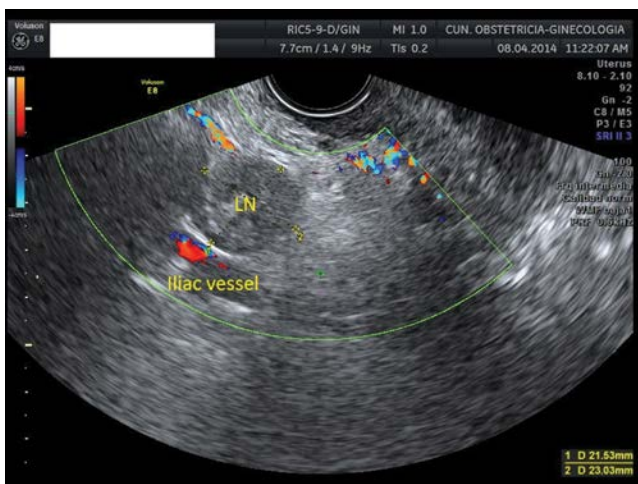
Transvaginal ultrasound showing a suspicious (>1 cm) pelvic lymph node (LN).
